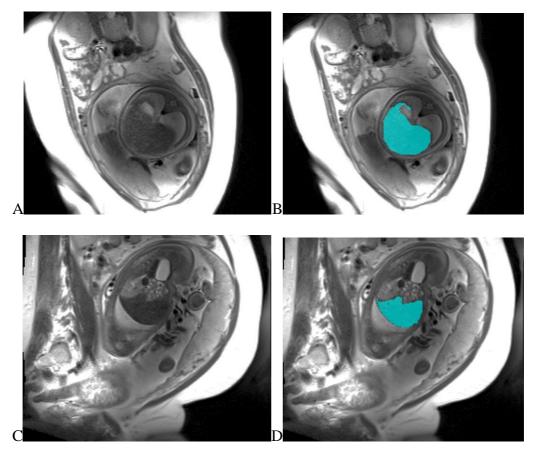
Fetal liver MRI images Uncoloured (A and C) and coloured (B and D) axial (A and B) and sagittal (C and D) slices to show the fetal liver.
